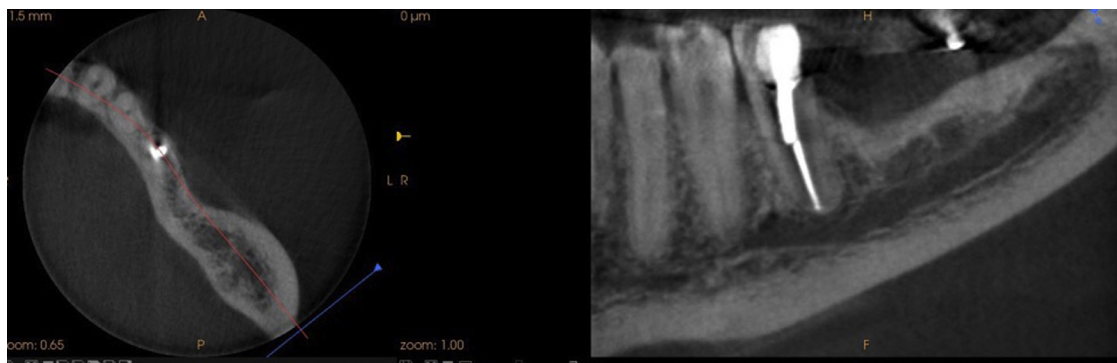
Computed tomography demonstrating a subtle radiopaque change in the region of the left mandibular buccal vestibular soft tissue approximating the extraction site of tooth 19.
